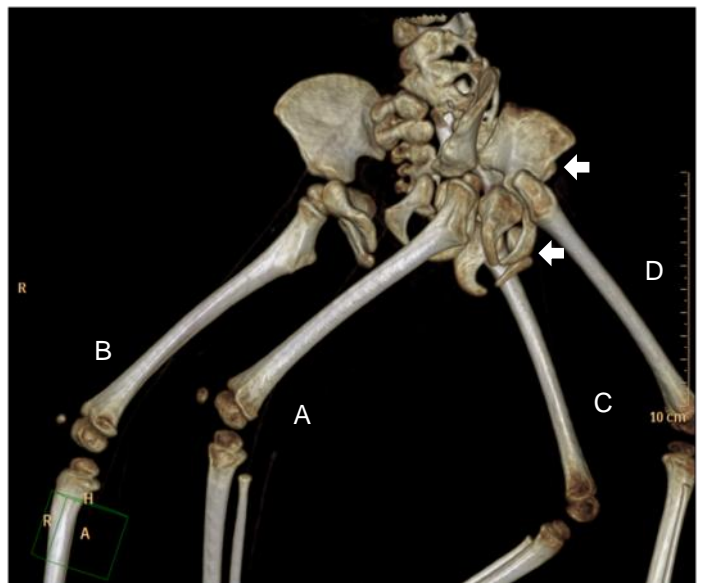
CT reconstruction demonstrating the skeletal framework of the patient's pelvic girdle, with limbs A and B arising from the autosite's pelvis and limbs C and D arising from the parasite's dysmorphic pelvis.
